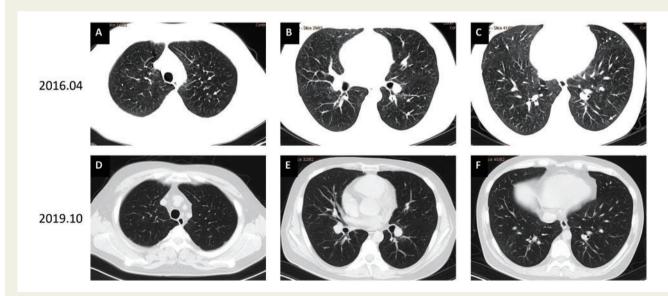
Computed tomography pulmonary angiogram at baseline (A–C) and 3-year follow-up (D–F) showed reduction in size and numbers of diffuse ground-glass shadows and nodular shadows (arrow).
